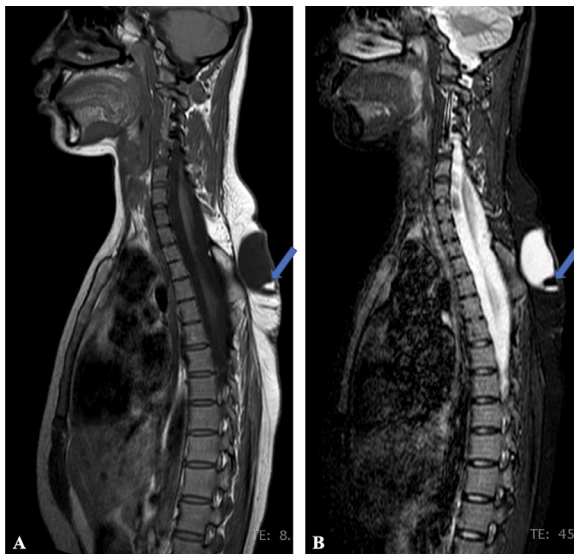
MRI sagittal images (Figure 3A-T1 weighted, Figure 3B-STIR sequence) demonstrate a high signal intensity area in the inferior aspect of the cystic protrusion (blue arrow in Figure 3A) which is suppressed in STIR sequence (blue arrow in Figure 3B), suggestive of fat component.
